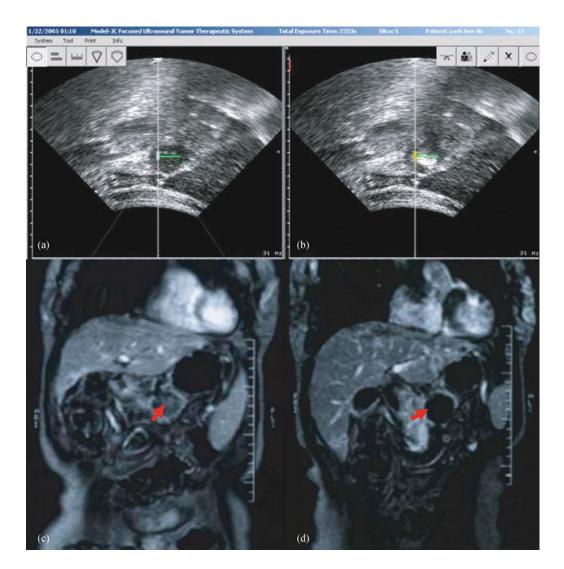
Real-time ultrasonography and contrast-enhanced MR images from a patient with pancreatic cancer. (a) Real-time ultrasound image before HIFU treatment reveals a hypoechoic lesion; (b) real-time ultrasound image during HIFU treatment shows massive gray-scale change in the tumor; (c) pretreatment contrast-enhanced MRI shows perfusion in the tumor (arrow); (d) one month after HIFU treatment, contrast-enhanced MRI shows the treated tumor with no enhancement (arrow). MRI: magnetic resonance imaging; HIFU: high-intensity focused ultrasound.
